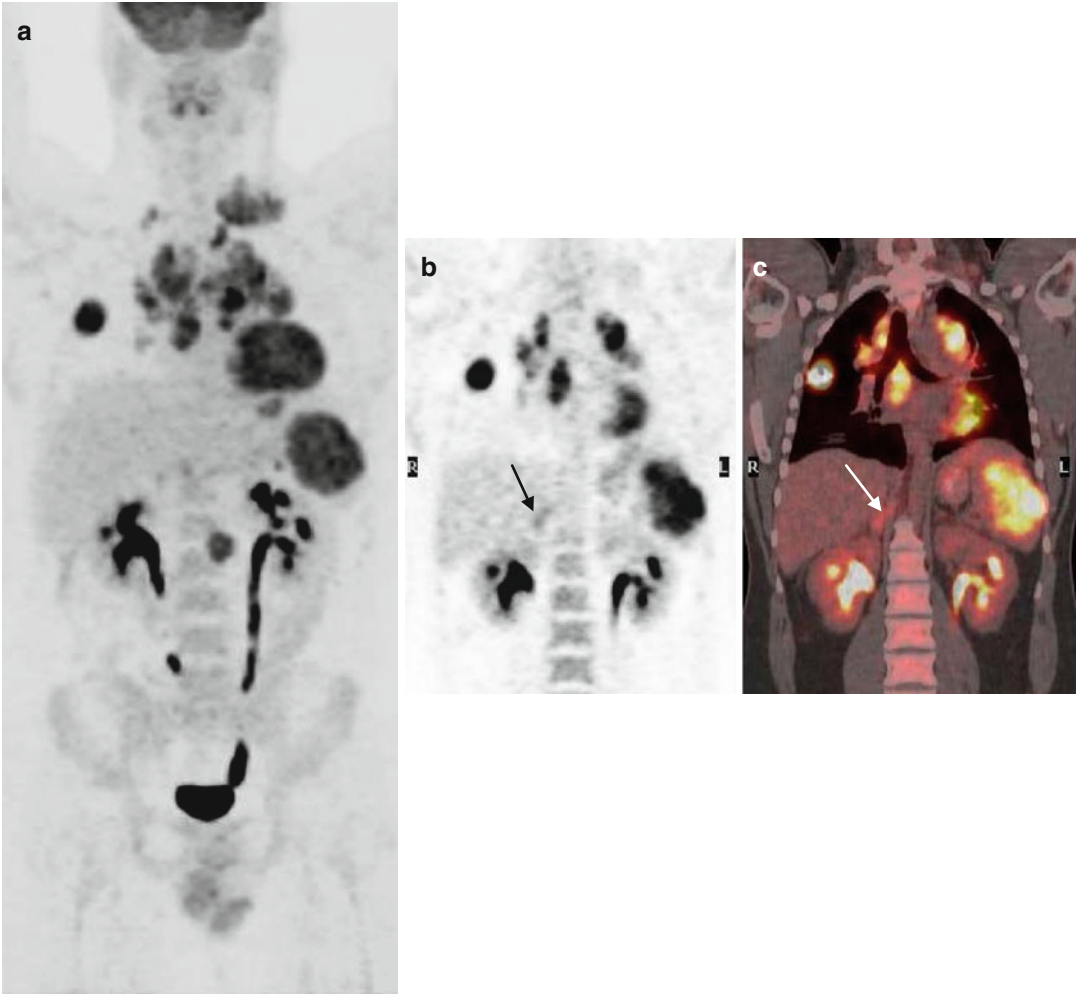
(a–c) PET/CT staging revealed bilateral cervical/supraclavicular, mediastinal, right hilar, and para-aortic lymphadenopathy, multiple focal splenic lesions measuring 4–8 cm, and a right upper lobe lung lesion. (a) The right adrenal hypermetabolic lesion (b, c – arrows) was not evident in initial CT
